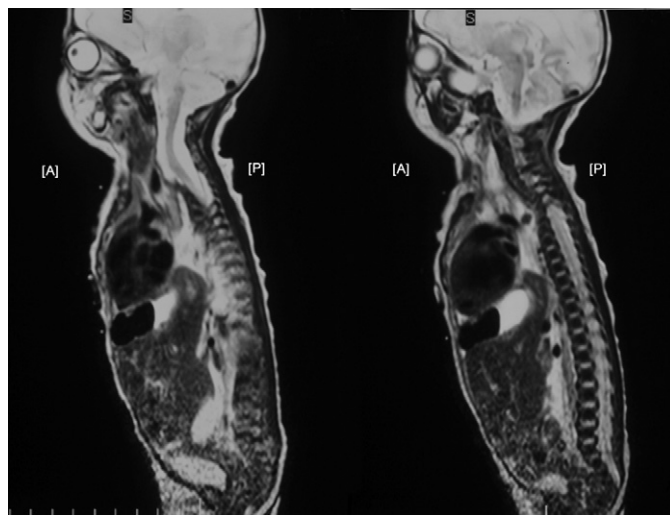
Sagittal T2 weighted MRI demonstrating a widened spinal canal and multiple level posterior cervical fusion.
